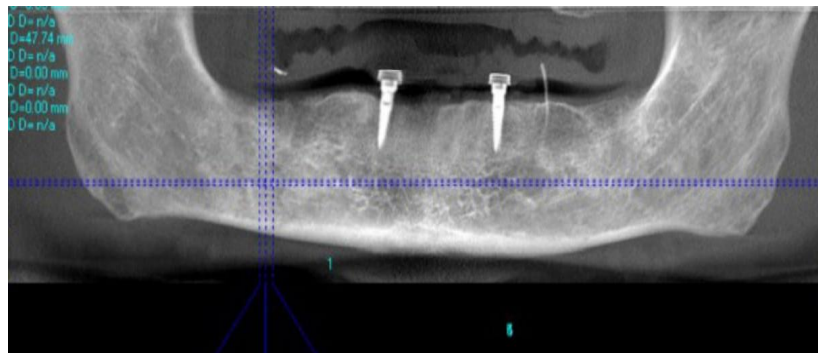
Shows the CBCT of two implants with Locator attachments
